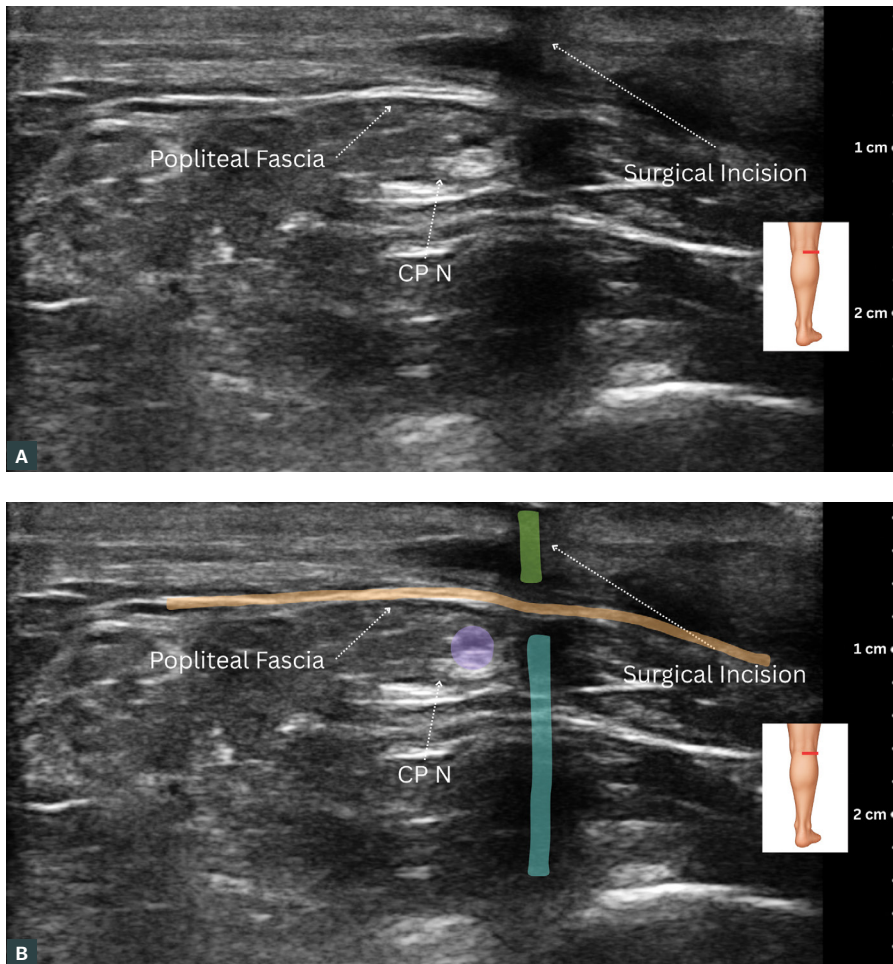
Case photos. A. Shows the common peroneal nerve in relation to the muscular fascia and the surgical incision. B. Annotated ultrasound scan of Figure 4A. Green: surgical incision site as shown by discontinuity of the skin and subcutaneous tissue. Surgical dissection was performed above the fascia. Orange: Popliteal fascia. Purple: Common peroneal nerve. Teal: Mild posterior shadowing, representing partial attenuation of the ultrasound beam with reduced echogenicity of the underlying tissues below the incision site.
